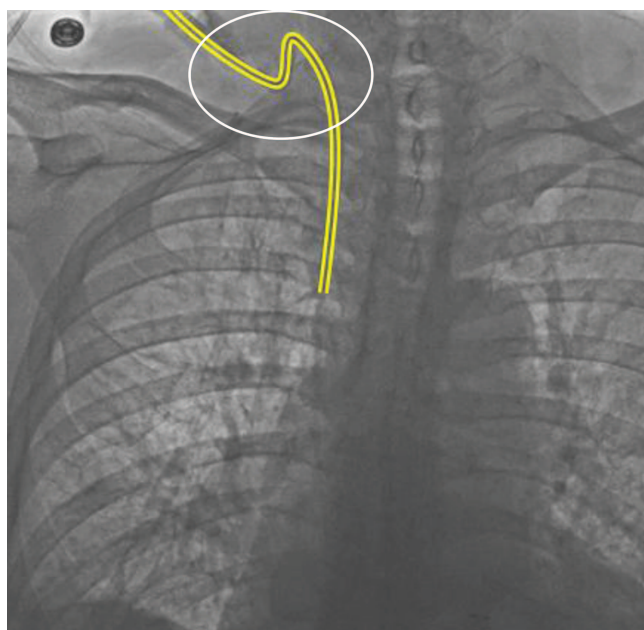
Radiographic identification of internal catheter kink (highlighted in yellow).
